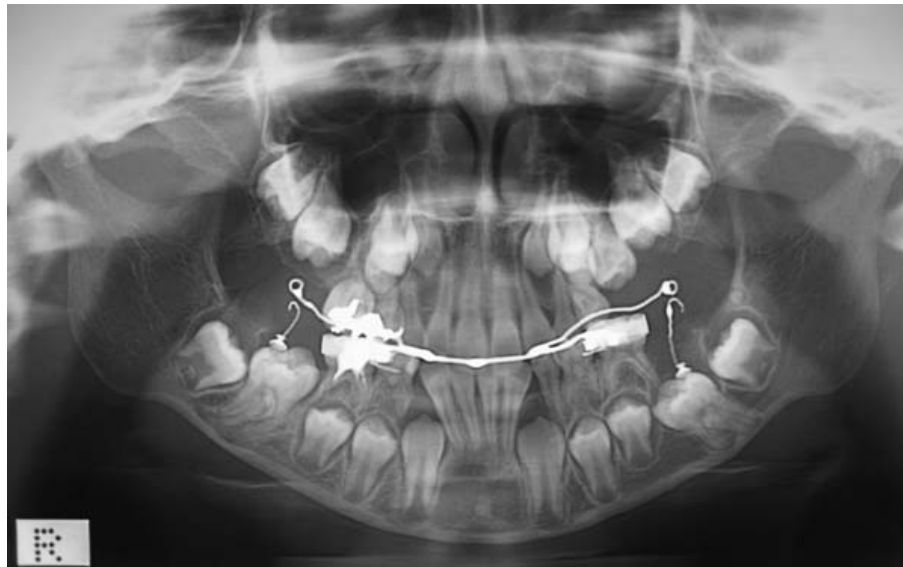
Panoramic radiograph during traction of the lower first molars (age 9 years 3 months).
